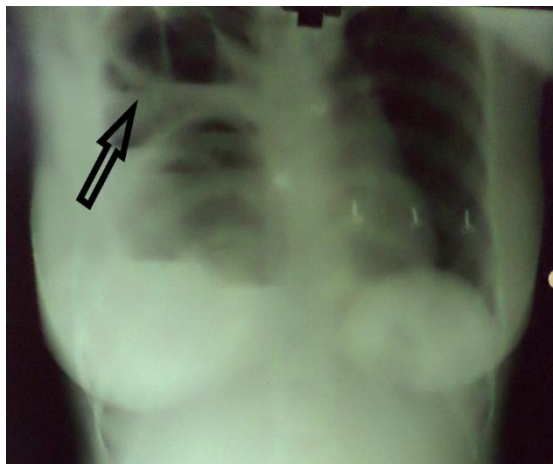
Chest X-ray showing air fluid levels in Right Hemithorax, suggestive of diaphragmatic hernia.
